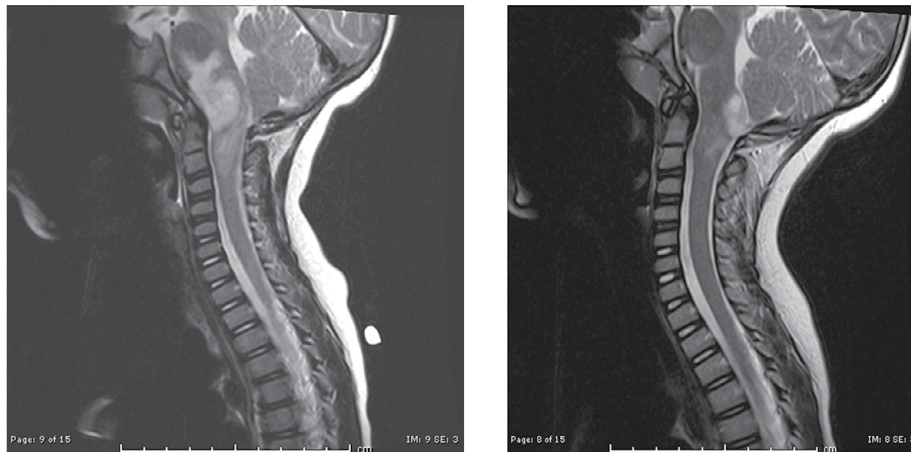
Sagittal T2-weighted MR imaging of a 4 year old boy with NF1 at baseline (left) and after two years of clinical and radiologic follow-up (right). He did not receive any tumor-directed therapy and the area of T2 hyperintensity and contrast enhancement (not shown) decreased without intervention.
